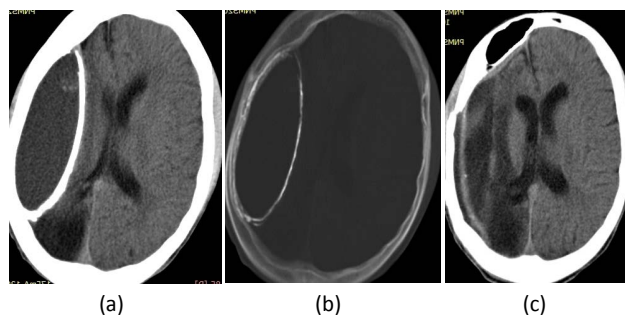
CT scan of the brain showing a large hemispheric mixed hyper dense lesion (a) and on bone window (b) an ossified rim which was totally removed (c).
